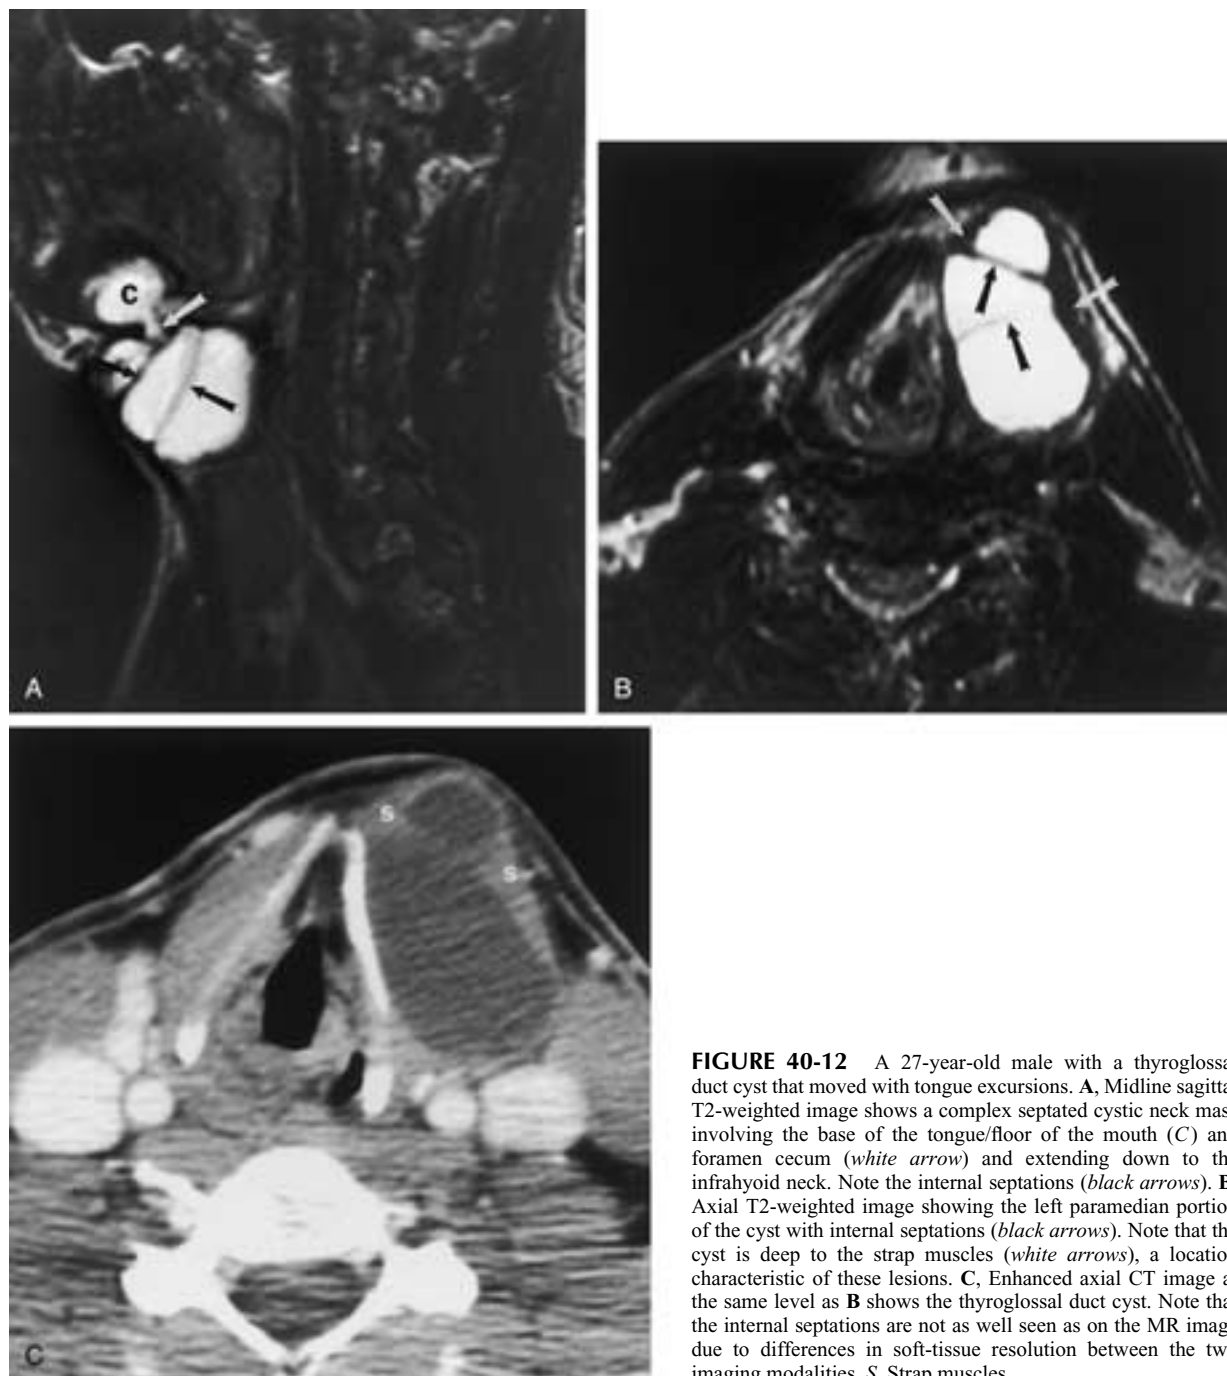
A 27-year-old male with a thyroglossal duct cyst that moved with tongue excursions. A, Midline sagittal T2-weighted image shows a complex septated cystic neck mass involving the base of the tongue/floor of the mouth (C) and foramen cecum (*white arrow*) and extending down to the infrahyoid neck. Note the internal septations (*black arrows*). B, Axial T2-weighted image showing the left paramedian portion of the cyst with internal septations (*black arrows*). Note that the cyst is deep to the strap muscles (*white arrows*), a location characteristic of these lesions. C, Enhanced axial CT image at the same level as B shows the thyroglossal duct cyst. Note that the internal septations are not as well seen as on the MR image due to differences in soft-tissue resolution between the two imaging modalities. *S*, Strap muscles.
